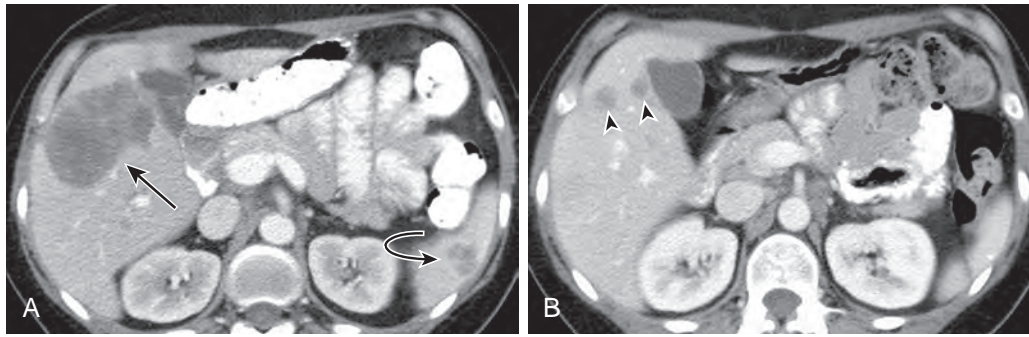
Handling of lesion splitting. Hepatic metastases in a 59-year-old woman with breast cancer. A. Initial axial contrast-enhanced CT demonstrated a large hepatic segment V lesion (*straight arrow*). Note splenic metastasis (*curved arrow*). B. Post-treatment axial contrast-enhanced CT image demonstrated splitting of the lesion into two smaller lesions (*arrowheads*). The sum of the longest diameter of each individual lesion is used on follow-up scan to assess for changes in tumor size.
